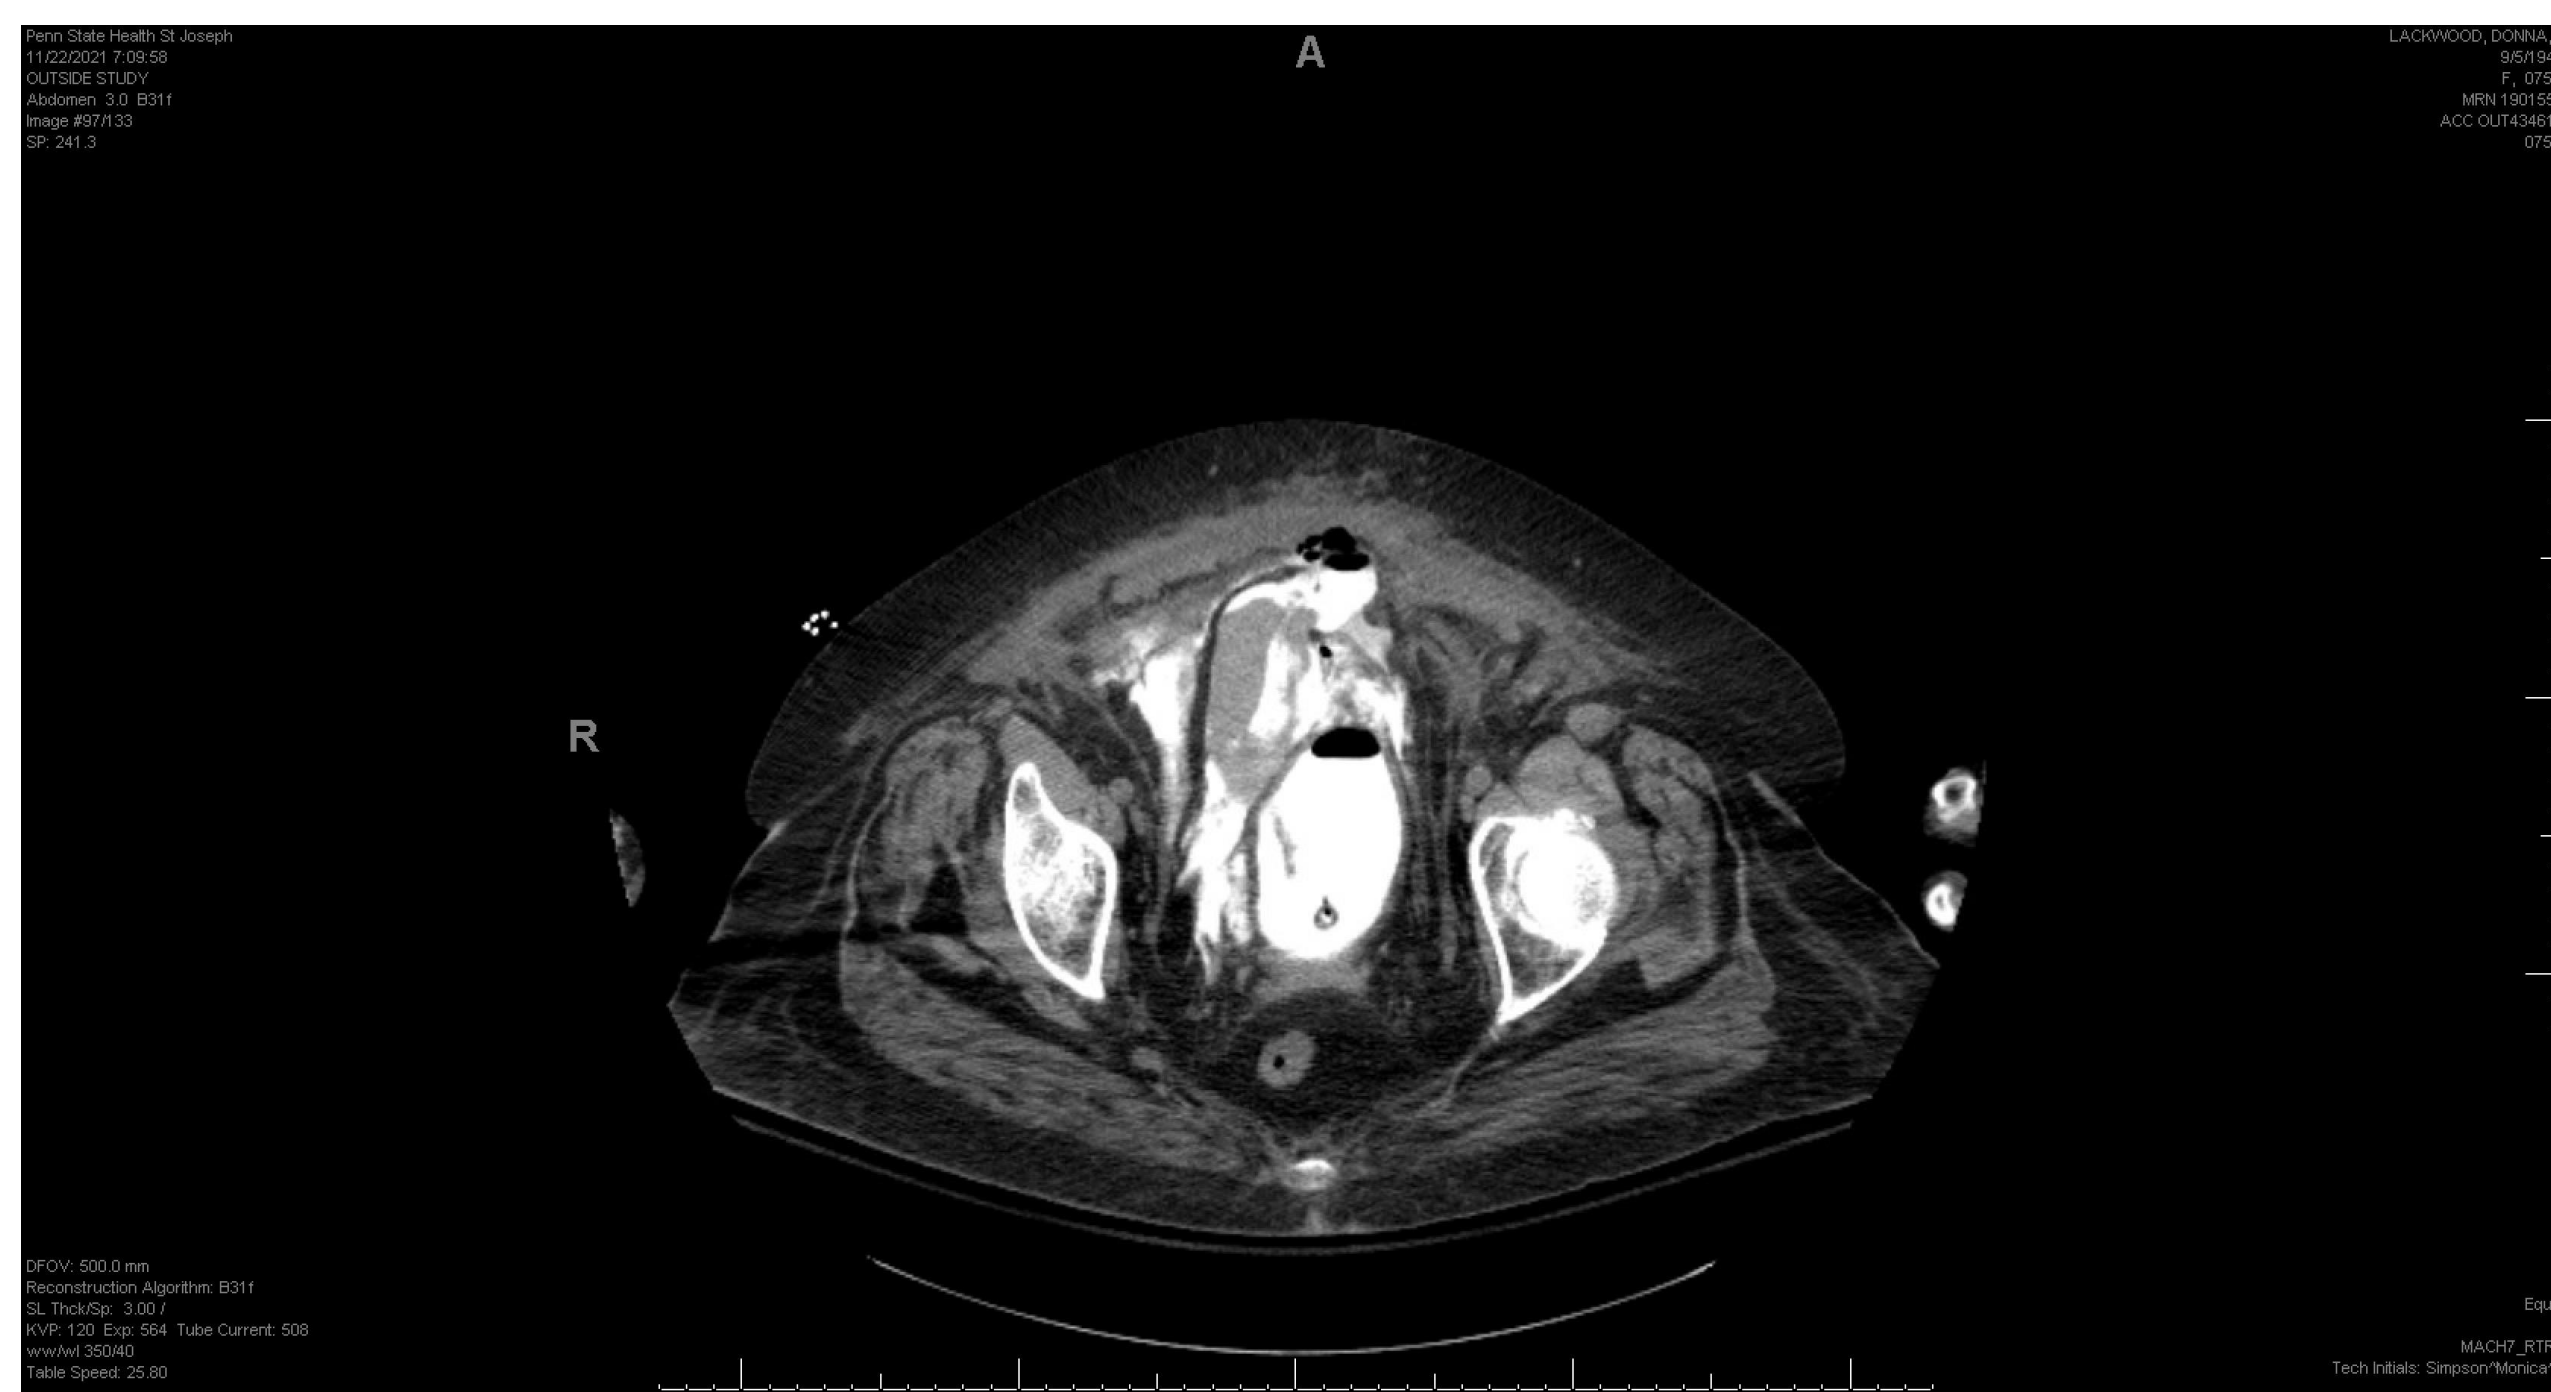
Transverse view of CT Abdomen demonstrating ascites in pelvis.
